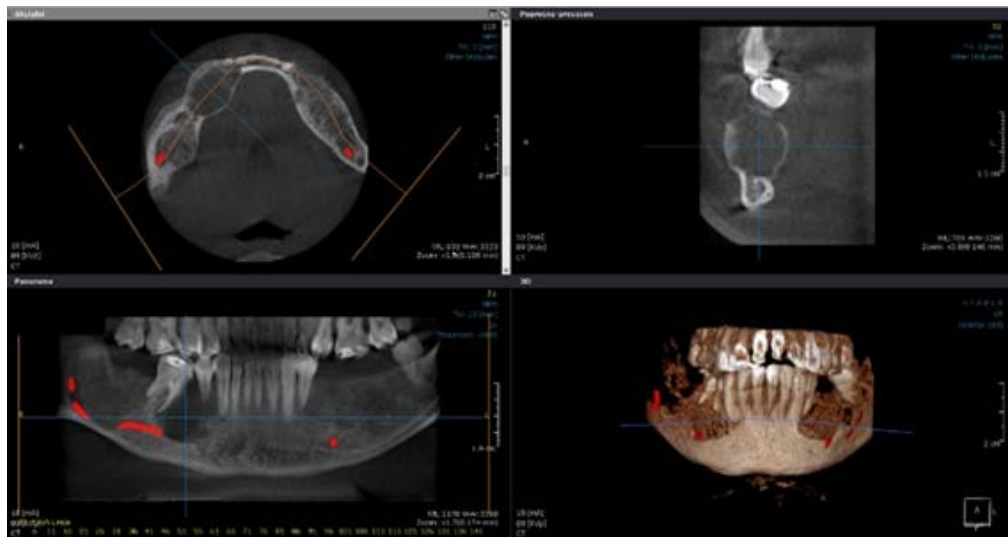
The initial appearance of the lesion on cone beam computed tomography in the region of the right side of the mandible.
